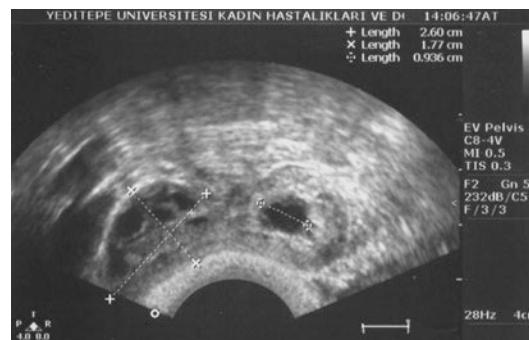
Tubal ectopic pregnancy sac on the right tuba uterina in the view of transvaginal ultrasonography
